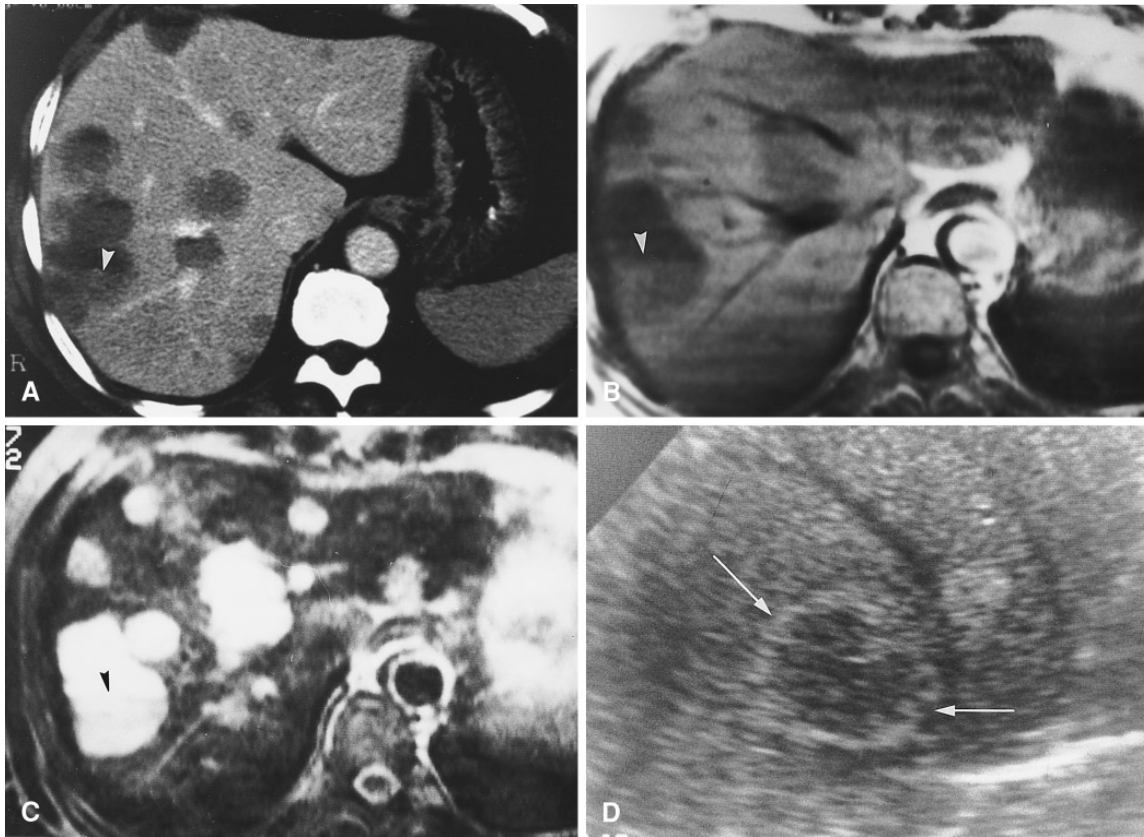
Fifty-eight-year-old-man with hepatic cavernous hemangiomas. A CT scan showed multiple lesions within the liver with some of them displaying internal horizontal fluid–fluid levels (*arrowhead*). B T1-weighted (450/15 msec) spin-echo MR image showed a fluid–fluid level (*arrowhead*) with inferior fluid layer hyperintense to muscle. Superior fluid layer was nearly isointense to muscle and hypointense relative to the inferior layer. C T2-weighted (2000/80 msec)
